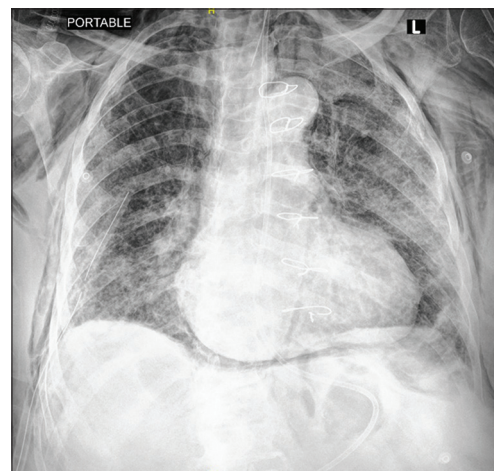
Chest X-ray showing pneumomediastinum with right chest tube
